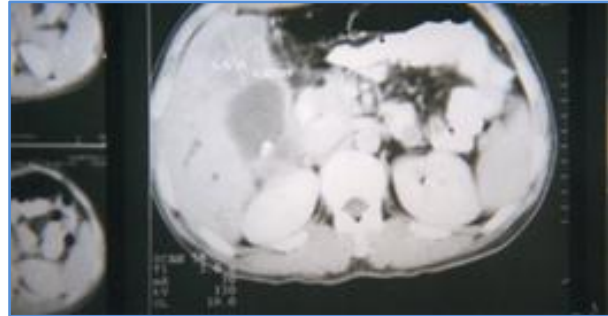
CT Scan showing mass in fundal region of gallbladder
